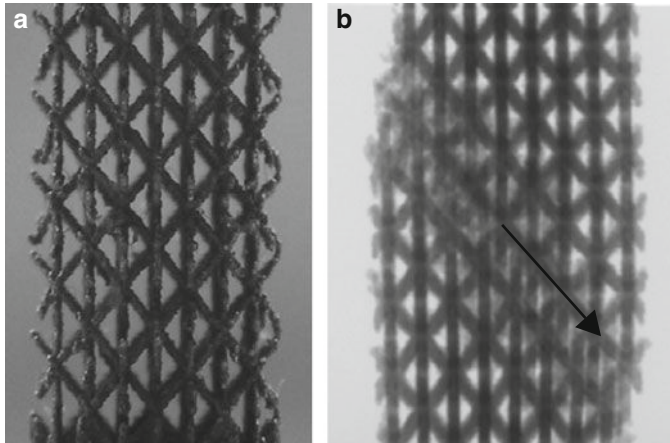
CT image of a porous titanium structure recorded using a Philips HOMX 161 X-ray system with the AEA TOMOHwk CT-software. Courtesy of Prof. M. Wevers, KULeuven
